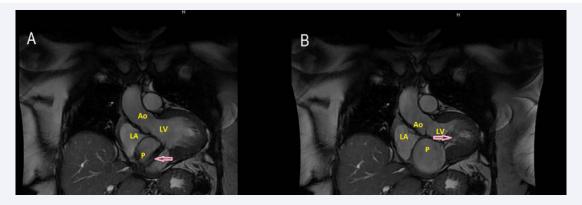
Panel A and B are 3 chamber views of the heart on MRI (SSFP). Pink arrow points at de-phasing protons, which indicate jet of blood. Ao: Aorta; LV: Left Ventricle; LA: Left Atrium; P: Pseudoaneurysm sac
